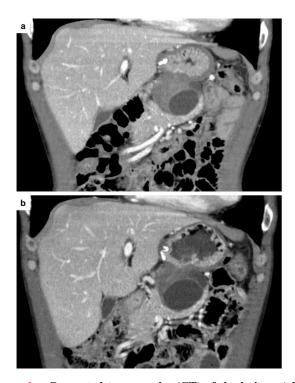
Computed tomography (CT) of the lesion. a) The coronal view at the referral showed a lesion consisting of a cystic component and an ill-enhanced solid component, located between the stomach and the pancreas tail. b) The coronal view at four months of follow-up showed that the cystic lesion had increased in size.
